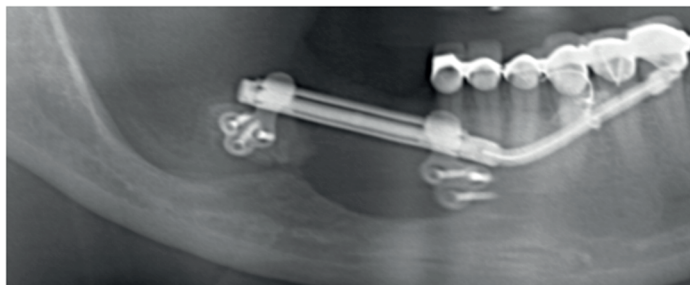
Radiographic view of the distractor and transport segment during consolidation period
